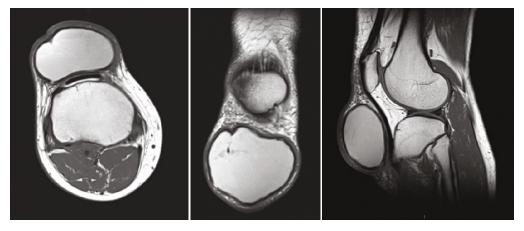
MRI scan of lesion.
